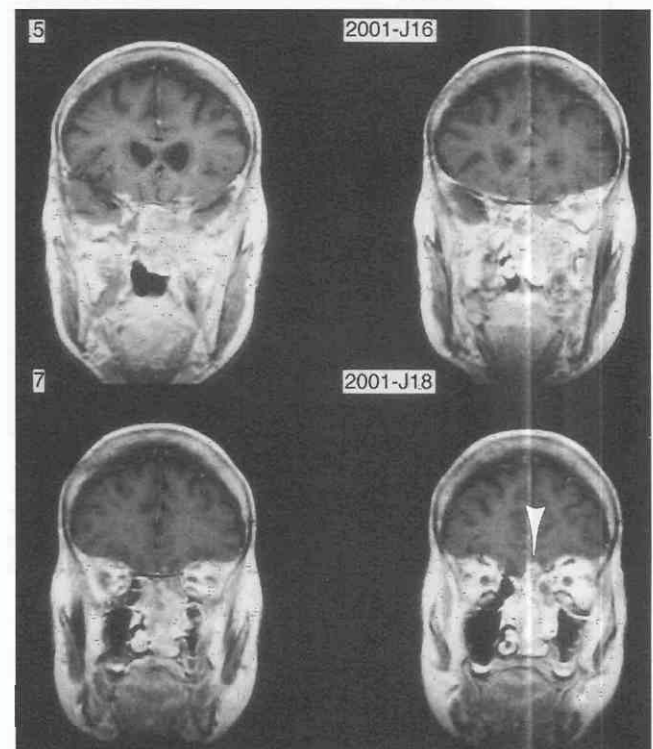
Esthesioneuroblastoma. Coronal T1-weighted postcontrast MRI scan. Marked enhancement of the mass is filling most of the nasal cavity. Intracranial extension is noted within the mass as it extends into the floor of the anterior cranial fossa on the left (arrowhead).
